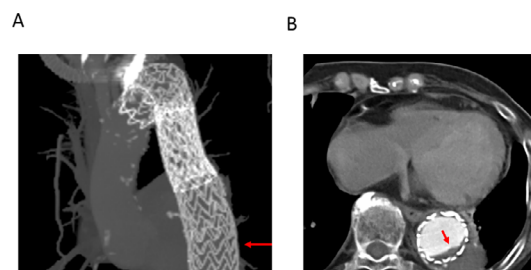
CT angiography images at the site of suspicious blood flow through the graft detected using non-obstructive angiography. (A) A minimal intensity projection image of the thoracic aorta. Two stent grafts (34×150 mm and 34×200 mm) were shown. The site of suspicious blood flow was at the level shown with a red arrow. (B) An axial image. Suspicious blood flow was detected through the graft using non-obstructive angiography (a red arrow).
